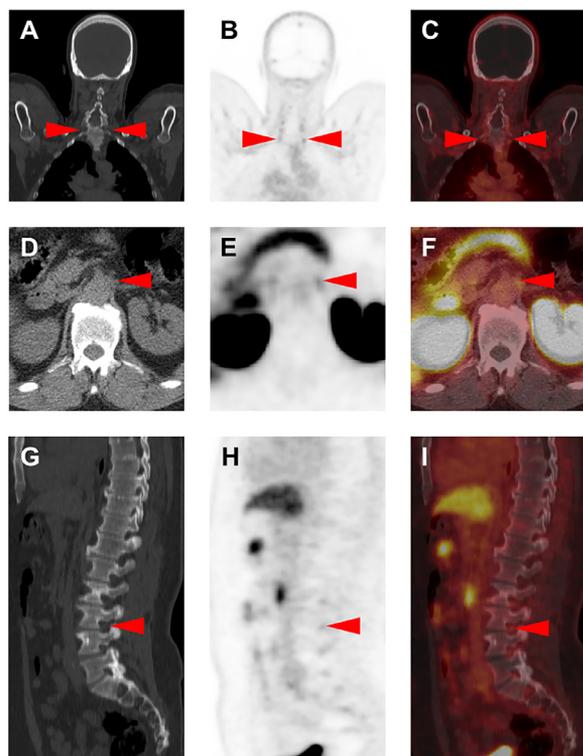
(A) Coronal, attenuation-correction CT, (B) coronal ^{18}F -DCFPyL PET, and (C) coronal ^{18}F -DCFPyL PET/CT images through the neck and upper chest of a 66-year-old man presenting for staging of high-risk prostate cancer and demonstrating radiotracer uptake in the cervical dorsal root ganglia and cervicothoracic/stellate ganglia (red arrowheads). (D) Axial, attenuation-correction CT, (E) axial ^{18}F -DCFPyL PET and (F) axial ^{18}F -DCFPyL PET/CT images through the upper abdomen showing radiotracer uptake in the left celiac ganglion (red arrowheads). (G) Sagittal, attenuation-correction CT, (H) sagittal ^{18}F -DCFPyL PET, and (I) sagittal ^{18}F -DCFPyL PET/CT images to the left of midline demonstrating uptake in lumbar dorsal root ganglia (red arrowhead).
